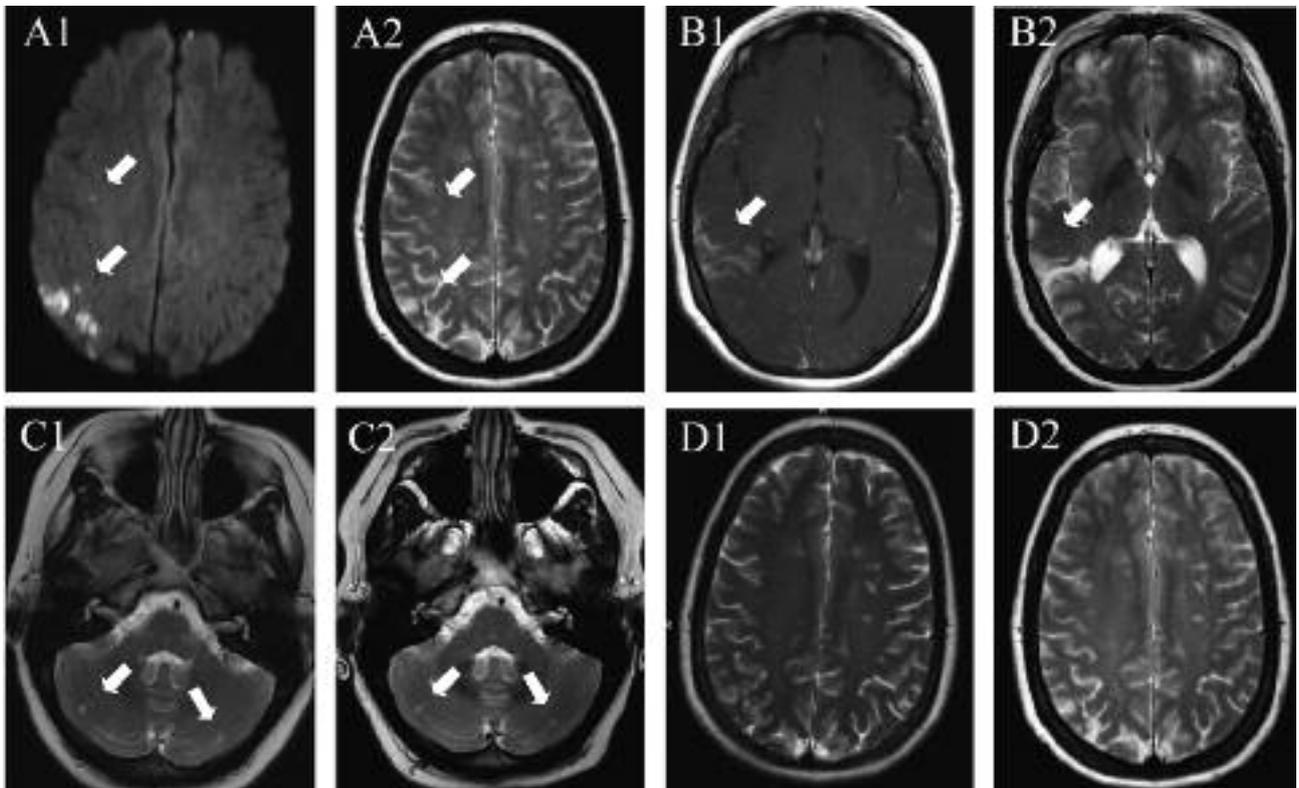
Transition of acute cerebral ischemia in the right parietal and frontal lobes as shown by axial diffusion-weighted ( $b = 1000$ ) MRI (arrows, A1) and of subacute cerebral ischemia in the right temporoparietal region as demonstrated by axial T1-weighted sequence (arrows, B1) to chronic infarction patterns in follow-up axial T2-weighted MRI after 6 months (arrows, A2 and B2). Cerebellar signal changes indicating chronic ischemia (arrows, C1) and supratentorial WML (D1) as shown on axial T2-weighted sequence remaining unchanged in follow-up axial T2-weighted MRI after 6 months (C2 and D2).
